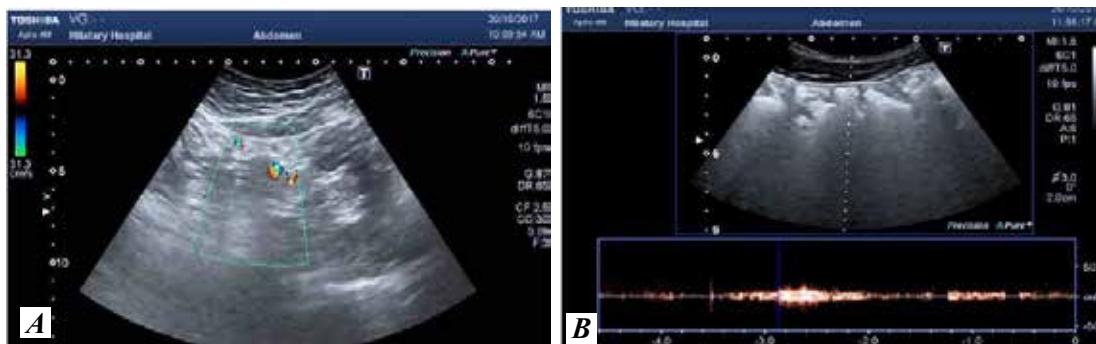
Duplex-Doppler examination of healthy subject intestinal peristalsis in control group
